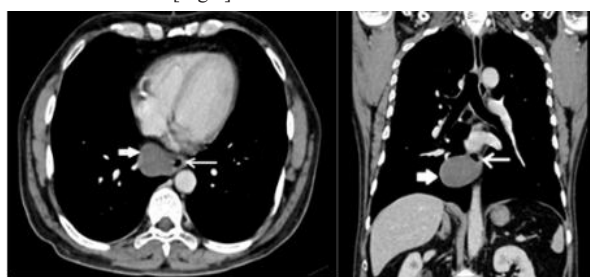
CT scan a. EDC (Solid arrow) b. Esophagus (thin arrow)
